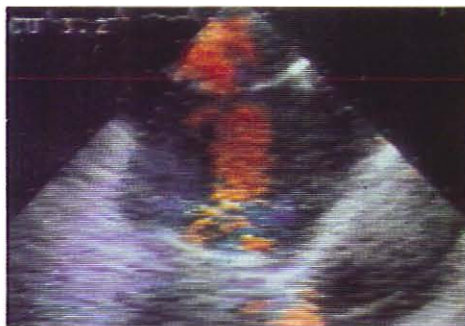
Transthoracic two-dimensional color Doppler echocardiogram demonstrating regurgitant flow through a Bjork-Shiley prosthetic valve (case 5). RF: regurgitant flow, BSV: Bjork-Shiley valve, PV: drainage flow from the pulmonary vein, CA: catheter for left atrial pressure monitoring.
